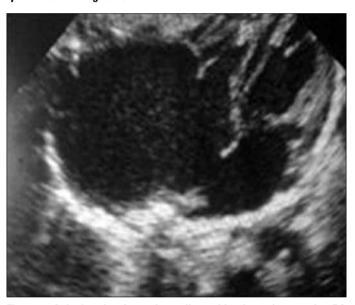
Apical 4-chamber echocardiographic view of a massive RA aneurysm
